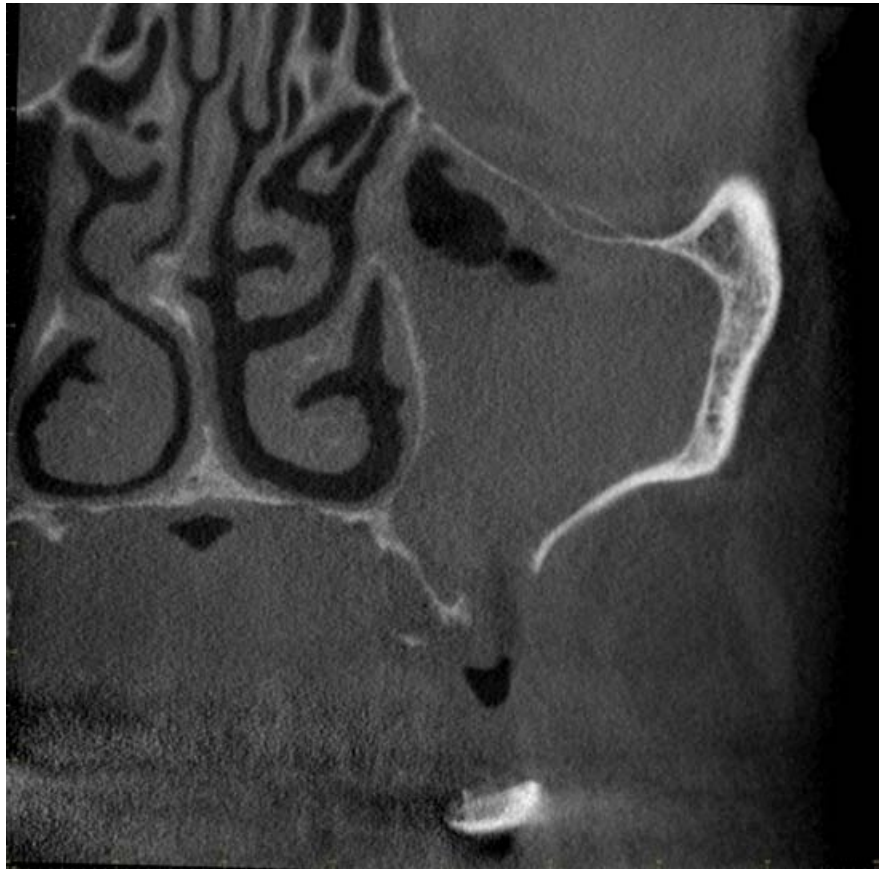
Coronal CBCT image at the region of the first molar with visible perforation of the cortical bone of the maxillary sinus
